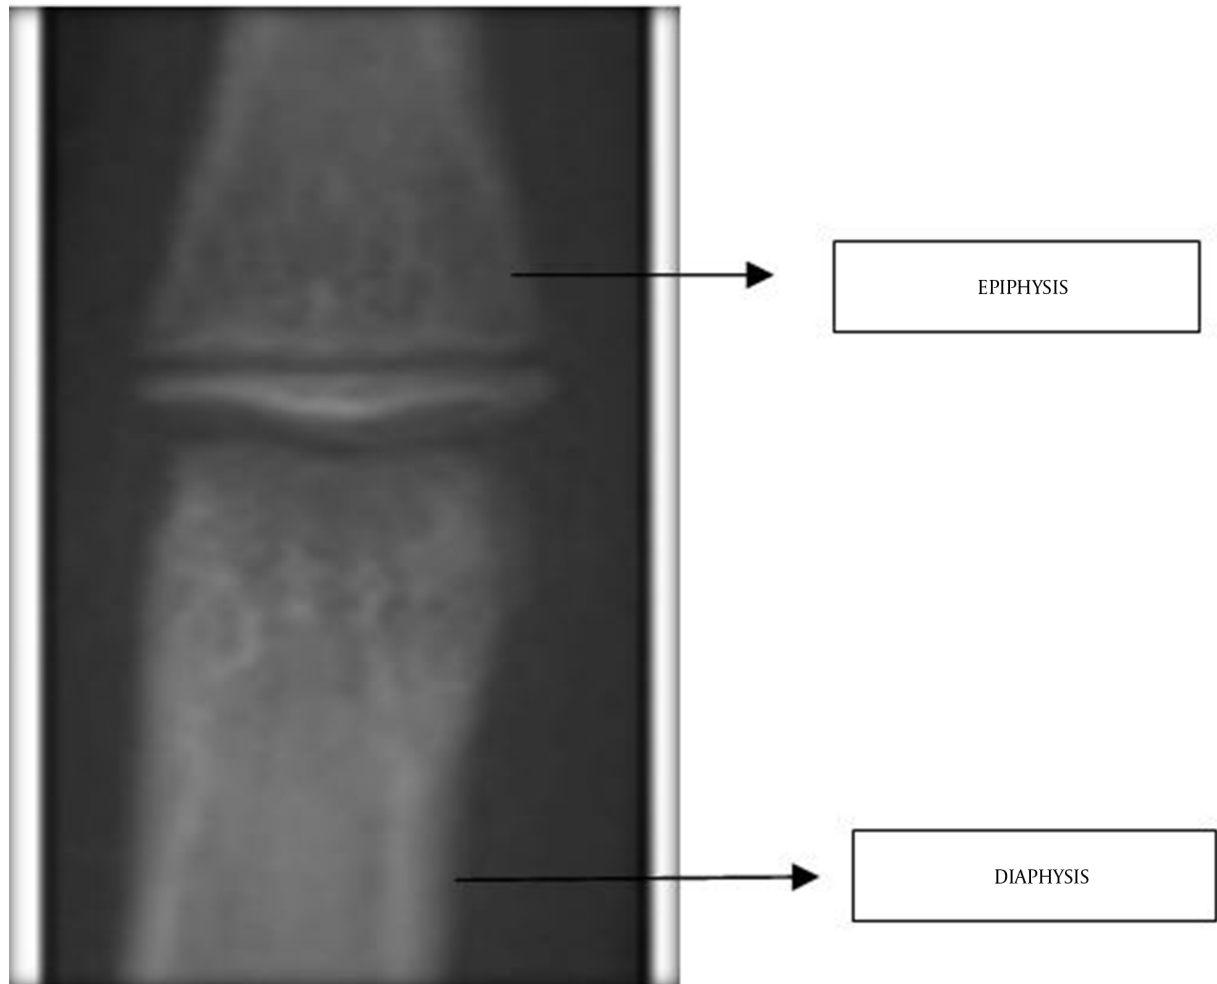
IOPA radiograph showing Middle phalanx of an adolescent
